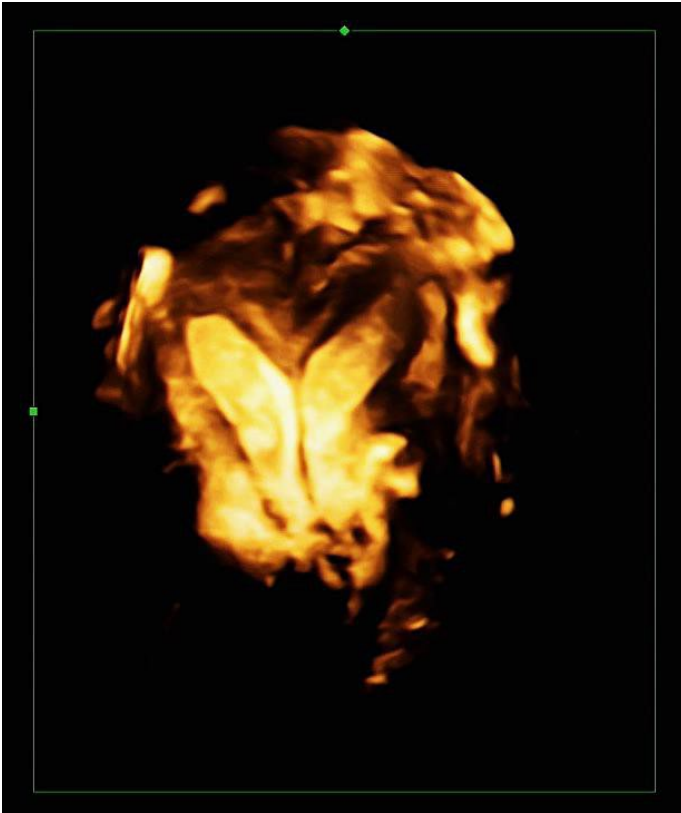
3D Ultrasound Image of Complete Septate Uterus - Class U2b.
